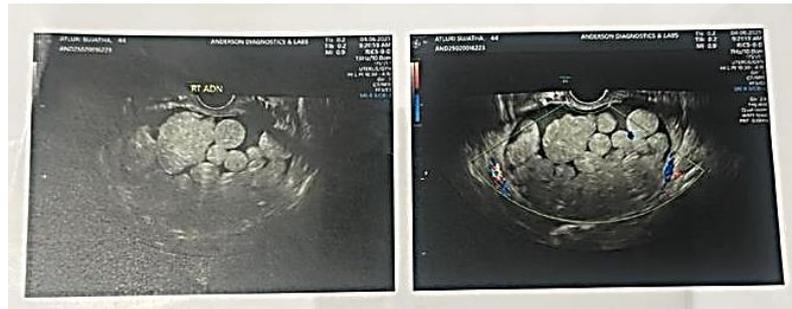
Ultrasonogram showing cystic lesion of right adnexa.
